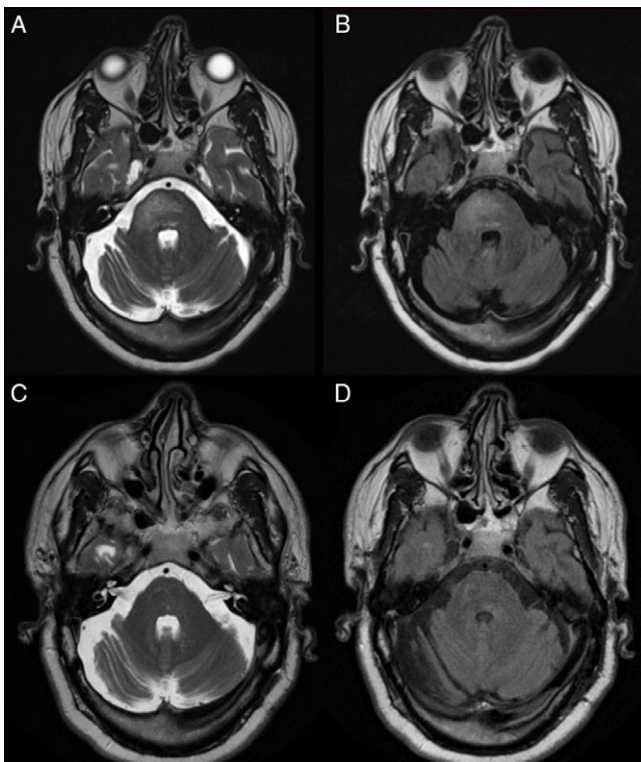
The patient was treated with 5 days of intravenous steroids, with an MRI 7 days after initial presentation revealing a marked decrease in enhancement on T2-weighted imaging (A) and fluid attenuation inverse recovery imaging (FLAIR, B). At 3 months, there was near complete lesion resolution on T2-weighted imaging (C) and FLAIR (D).
